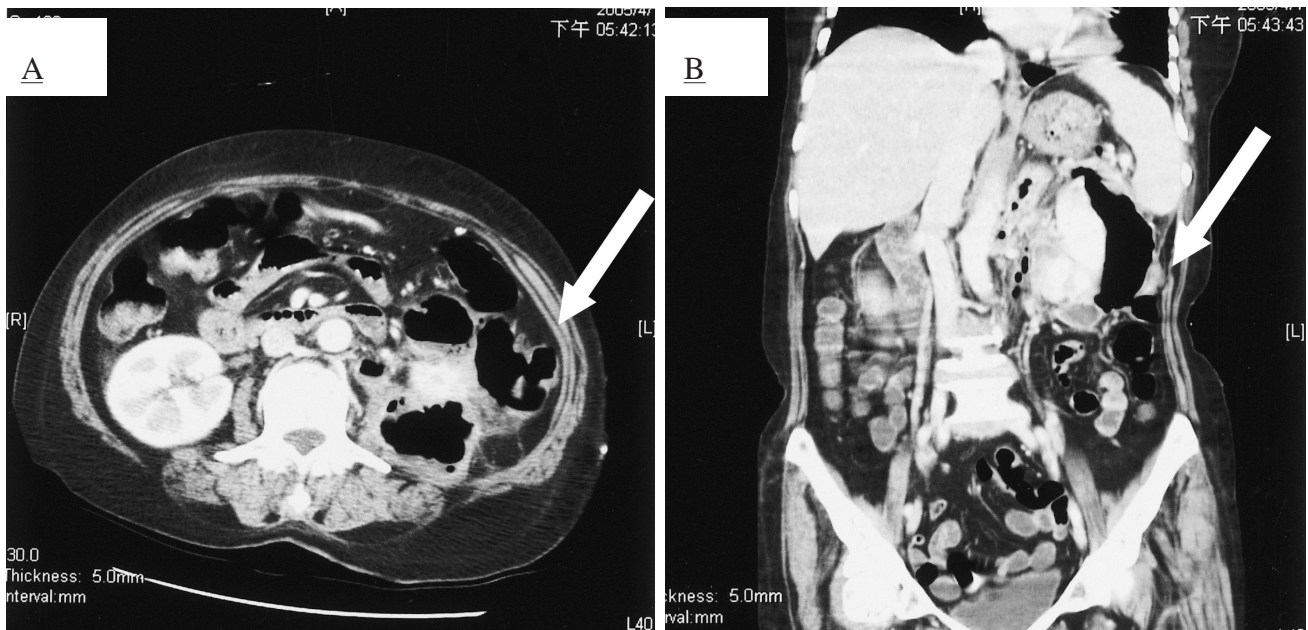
Abdominal contrast-enhanced computed tomography image studies in a 73-year-old woman with one-month indolently left-flank soreness, cross section (2a) and coronal section (2b) show left perirenal abscess, left subdiaphragmatic abscess, a fistula between perirenal space and gastrointestinal tract (arrow), and soft tissue pneumatosis with direct extension to the major vascular pedicle.
